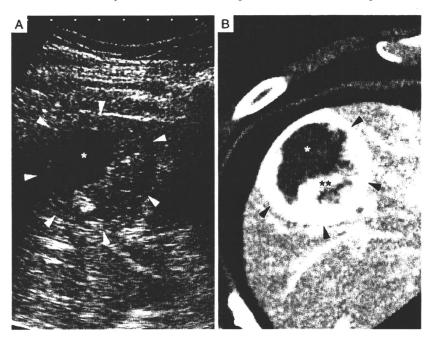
(A) Abdominal ultrasound image shows a well-defined mass with a cystic component (*) in segment VIII of the liver. The solid component shows a heterogeneous area with a mosaic pattern (white arrowhead). (B) Computed tomography hepatic arteriography shows a well-defined tumor consisting of a marginal well-enhanced area (black arrowhead) with an internal poorly enhanced area () and a cystic area (*).
